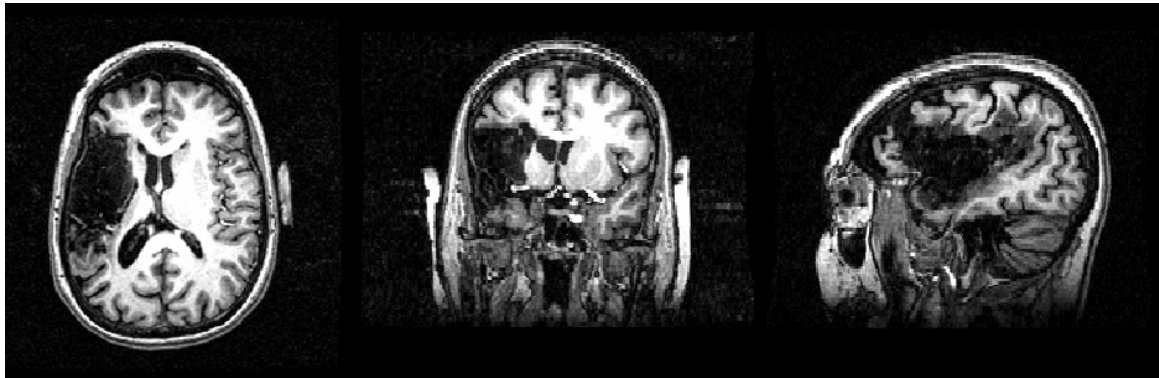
Axial, coronal and sagittal magnetic resonance images of the patient's brain. Left hemispheric 9 month old ischemic vascular lesion. Functional deficit circumscribed to non-fluent aphasia.
